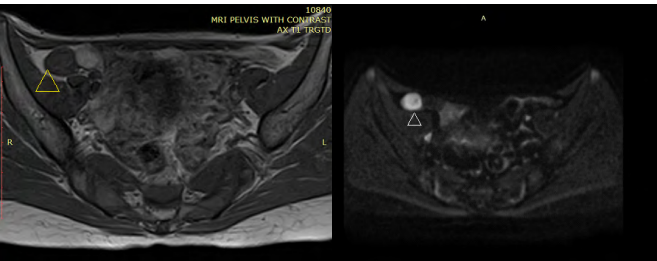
MRI abdomen and pelvis. Absent uterus and ovaries with rudimentary vagina and undescended testes yellow and white triangle.
